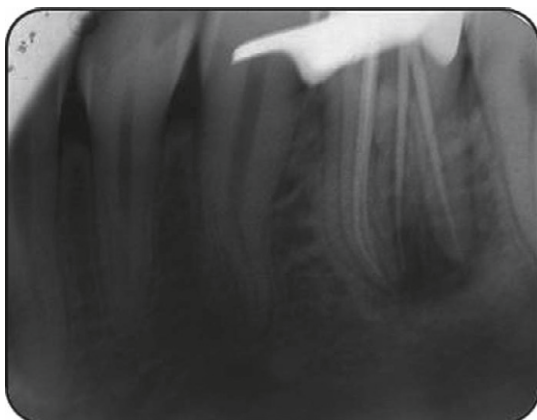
Master cone radiograph of mandibular left first molar.
